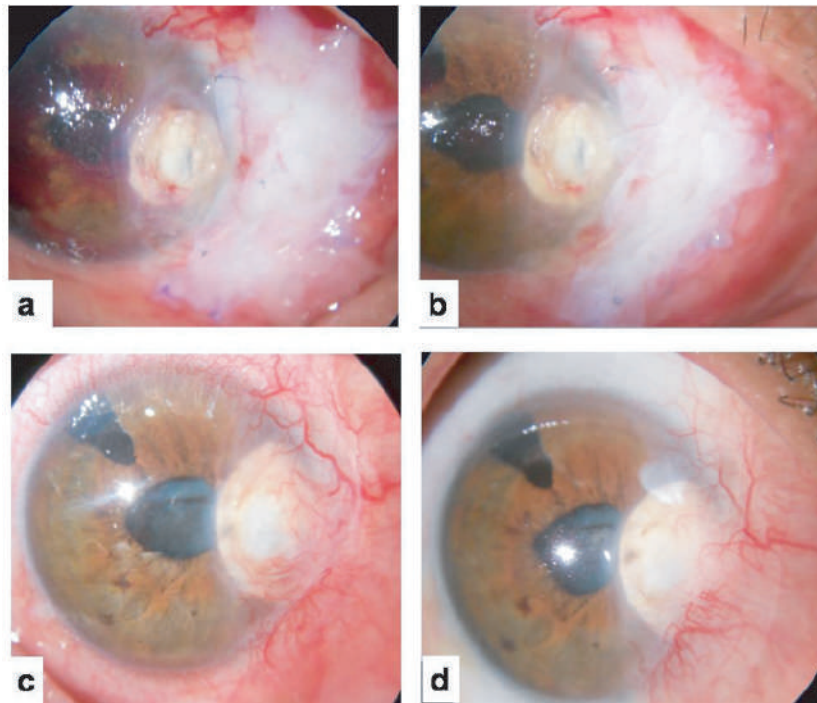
(a) Sealed corneal perforation 72 hr after surgery (scleral patch, CTA plug, and double layered AMG in place). (b) Corneal perforation sealed and corneo-limbo-scleral necrosis at healing stage at two-weeks' follow-up. (c) Healed corneal perforation (sclera patch in place) and pseudo-ptyerygium at 12 weeks' follow-up. (d) Healed corneal perforation (sclera patch in place) and pseudo-ptyerygium at 18 months' follow-up.
